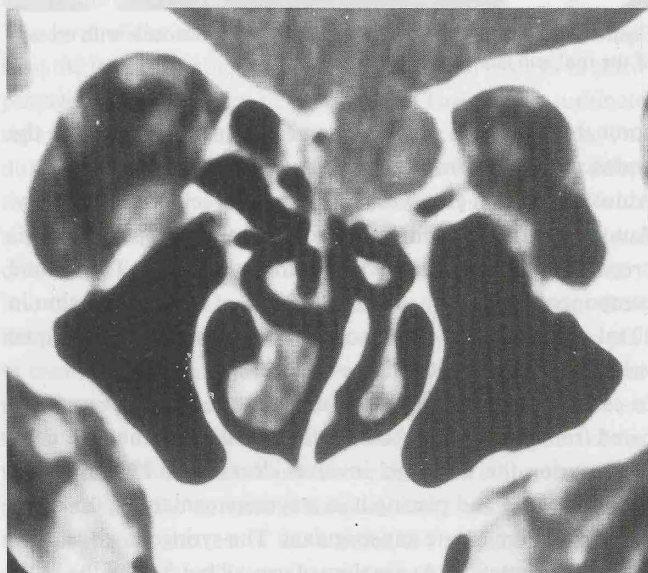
Coronal CT-scan of a mucocoele of the ethmoid sinuses with erosion of the cribriform plate and CSF leak.
